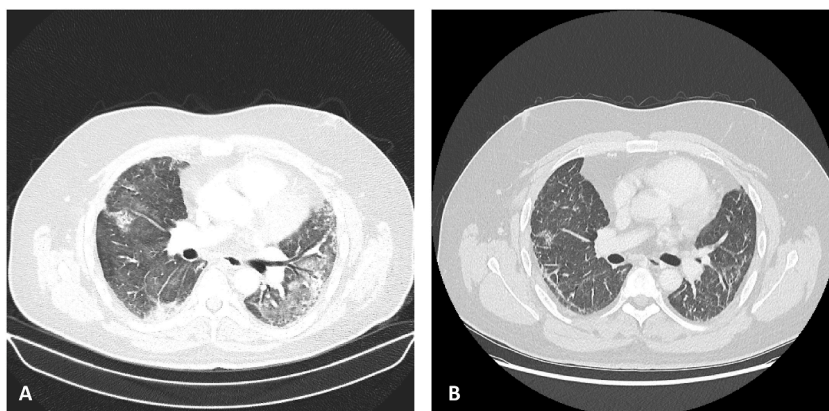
Chest CT before (A) and after (B) bleomycin induction.
